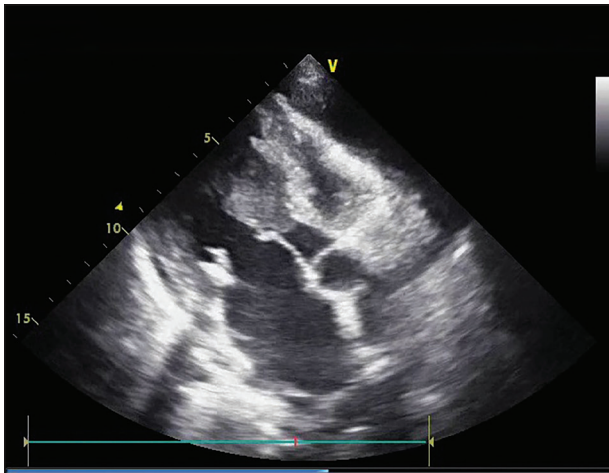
Transthoracic echocardiography view of the mass obstructing the left ventricular outflow tract.
